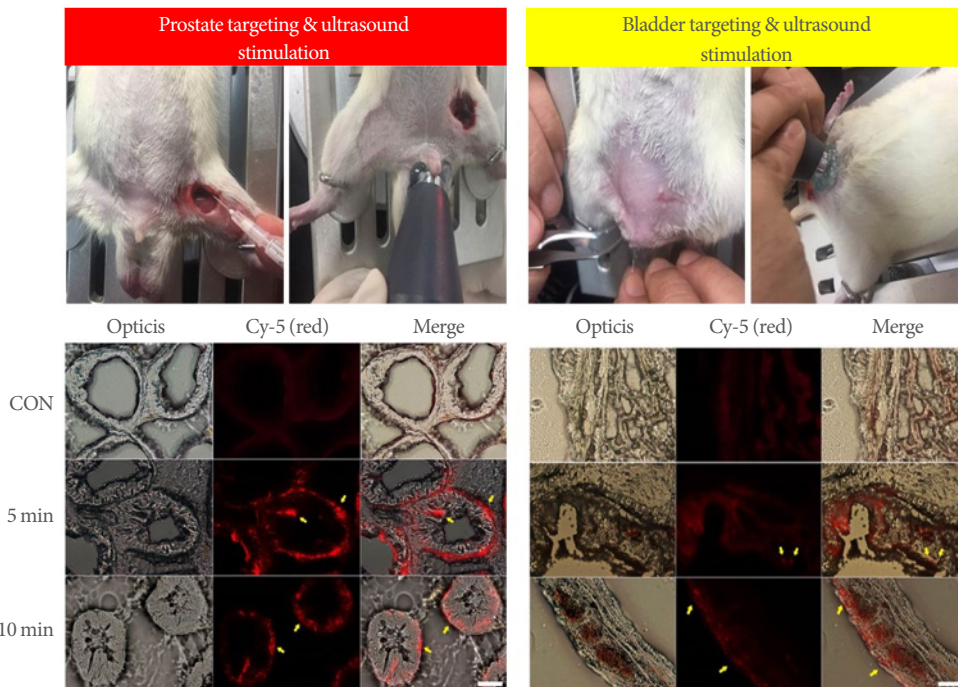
Analysis of the ultrasound stimulation protocol for microbubbles.
